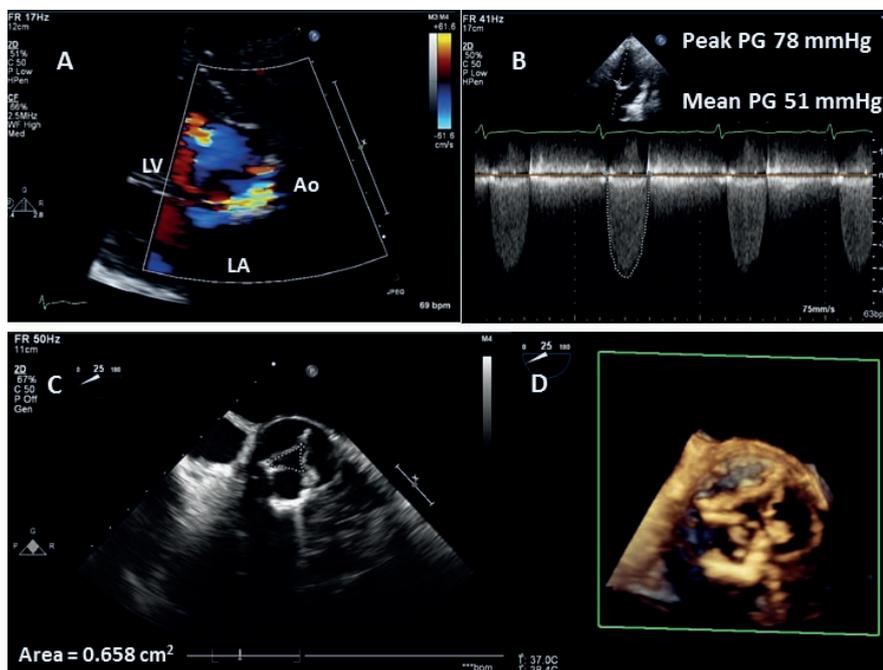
Degenerative bioprosthetic aortic valve with severe aortic stenosis and regurgitation. Transthoracic echocardiography demonstrating an eccentric jet (A) of aortic regurgitation during diastole along with an increased systolic pressure gradient across the aortic valve with a round contour (peak pressure gradient of 78 mm Hg and a mean pressure gradient of 51 mm Hg) (B) which is consistent with severe aortic stenosis. There was also severe aortic regurgitation (with diastolic flow reversal in the descending aorta, not shown here). On transesophageal echocardiography in the short-axis view (C) there is restricted opening of the valve cusps with a planimetered valve area of 0.66 cm² and leaflet thickening on three-dimensional transesophageal echocardiography (D). Ao, aorta; LA, left atrium; LV, left ventricle.
